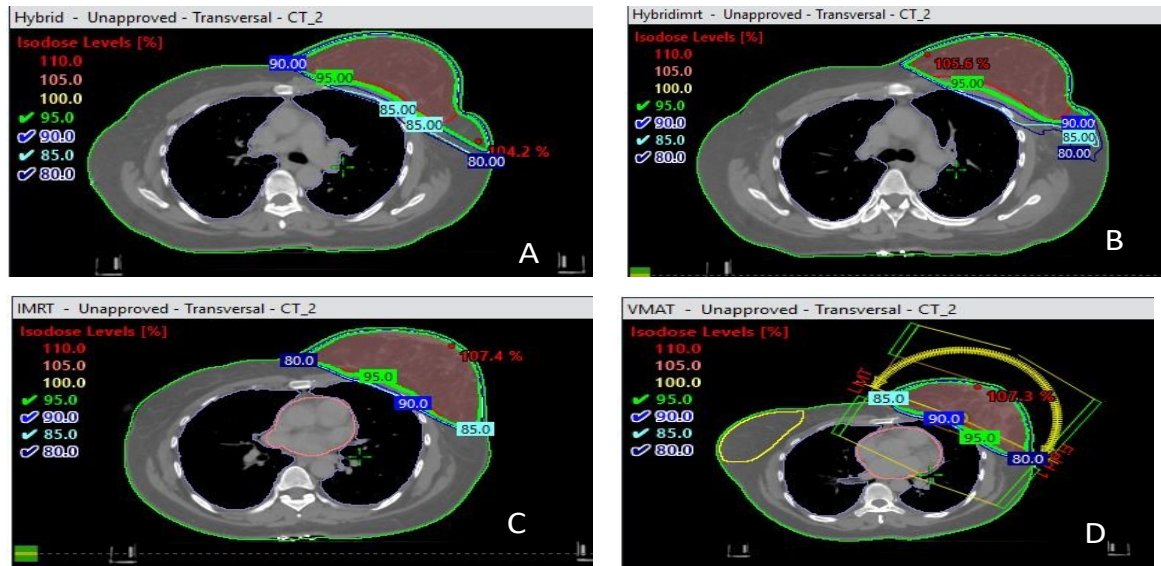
Axial CT images with contoured structures and dose distribution for the four techniques; A. Hybrid (2 beams), B. Hybrid (5 Beams), C. IMRT, D. VMAT.
